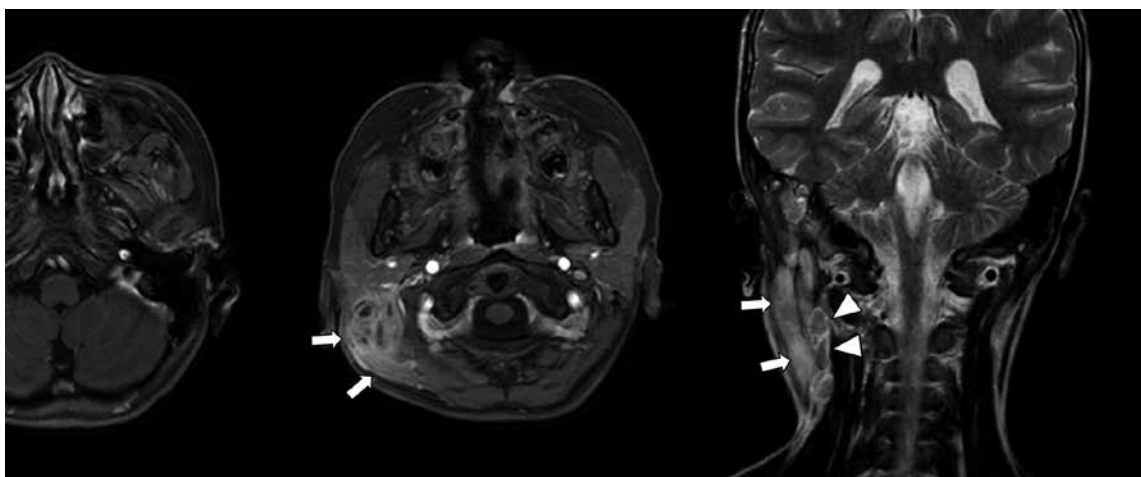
Magnetic resonance imaging (MRI) (T1-weighted, Gd contrast) on hospital arrival. Pale high-signal area in the right mastoid cell and contrast effect along the mastoid process to the sternocleidomastoid muscle (arrows). Ring-enhancement lesions are seen in some areas (arrowheads).
